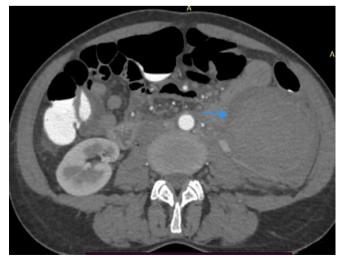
Computed Tomography Angiography showing large retroperitoneal hematoma (8.3 cm x 7cm)
